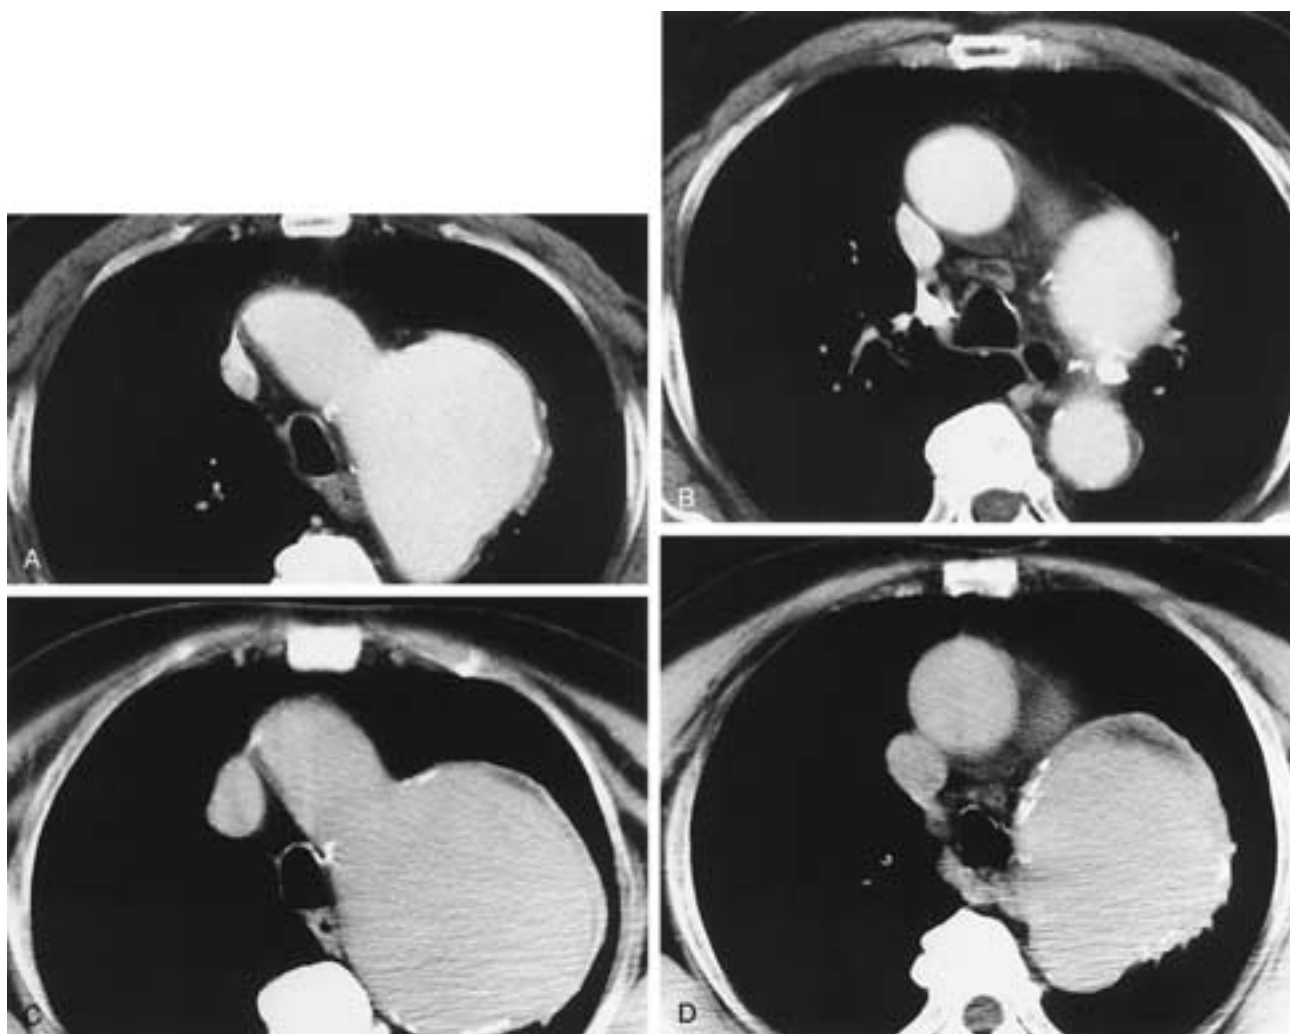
Aortic aneurysm. Axial CT scans in June 1993 (A and B) and March 1995 (C and D) show an aneurysm of the aorta. The aneurysm extends into the AP window. The enlargement of the aneurysm resulted in a left vocal cord paralysis. There was normal cord mobility in June 1993.
